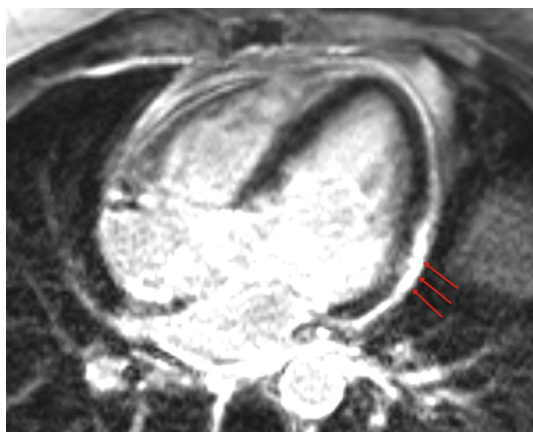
An example of cardiac MRI with delayed enhancement identifying subepicardial scar in the lateral left ventricle (red arrows) in a patient with postmyocarditis VT. Endocardium is preserved without wall thinning. Endocardial ablation in this patient has little chance to be successful.
